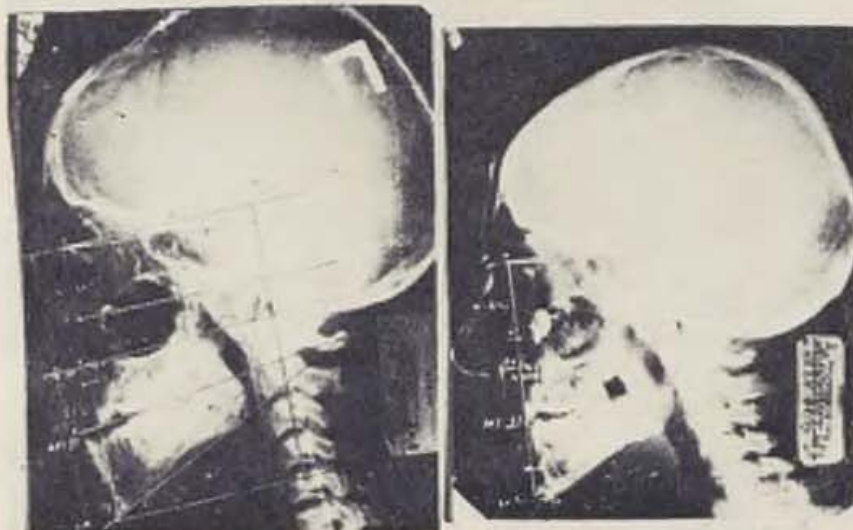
Patient E. Tele X-ray before and after the treatment.
